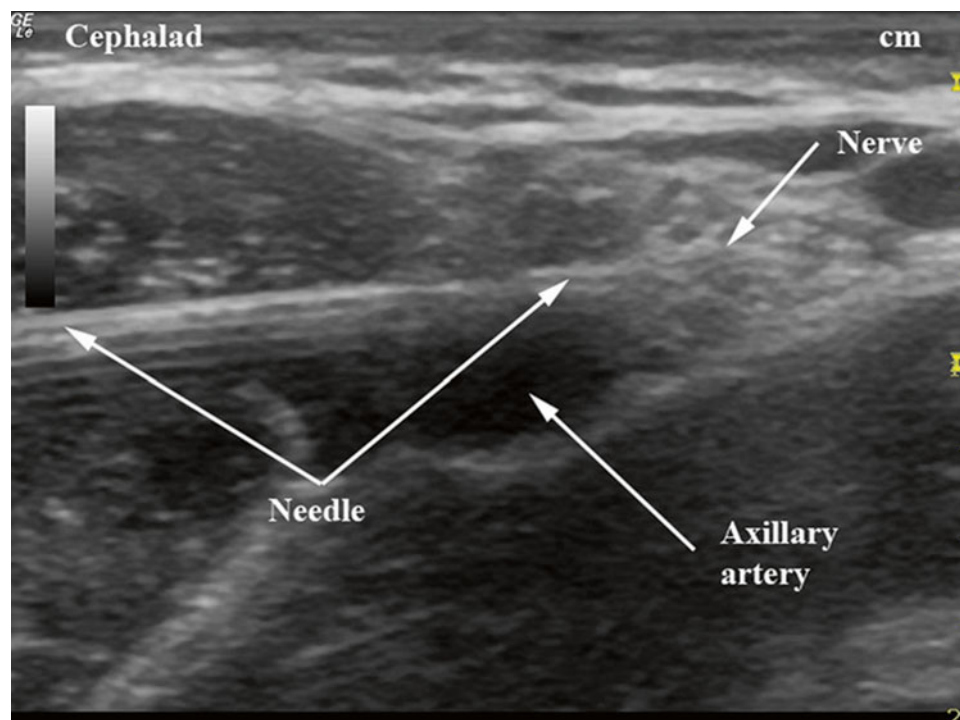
Ultrasound needle placement for axillary brachial plexus block (With permission from Buckenmaier and Bleckner [71])
